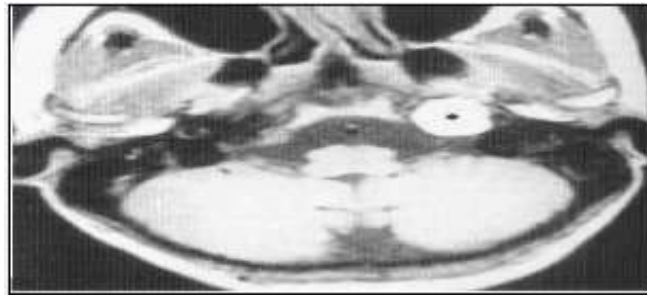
MRI T1WI shows cholesteatoma[10]
